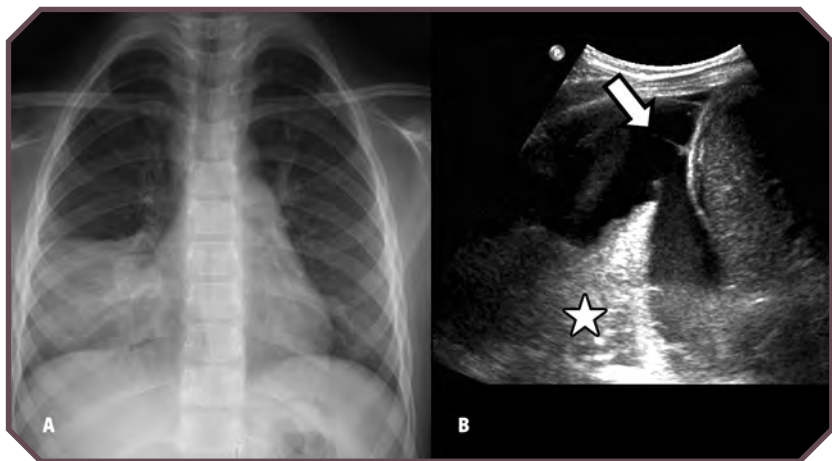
Empyema in a 3-year-old girl with fever and lower-lobe pneumonia. A. Frontal chest radiograph shows right lower-lobe opacity. B. Longitudinal ultrasonographic image demonstrates a hypoechoic pleural collection (arrow) surrounding the lower lobe (star).
